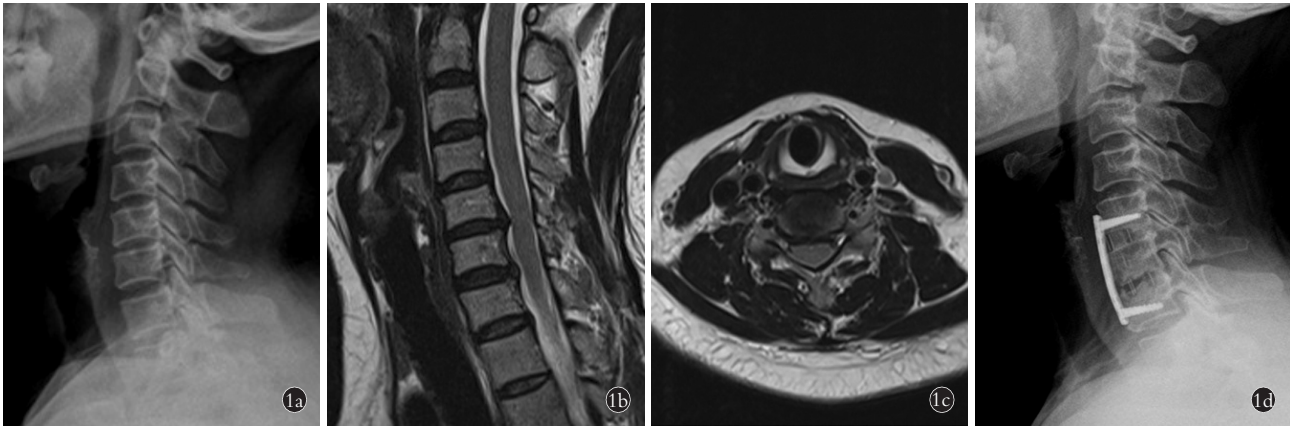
女性患者,47 岁,C₅-C₇ 两节段脊髓型颈椎病,行 ACDF 术 1a. 术前颈椎侧位 X 线片 1b,1c. 术前颈椎 MRI 中 T2 加权影像显示 C₅-C₇ 两节段椎间盘突出,脊髓受压 1d. 术后 12 个月随访时侧位 X 线片示颈椎 C₅-C₇ 节段内固定稳定,椎间融合器无明显下沉,位置良好
